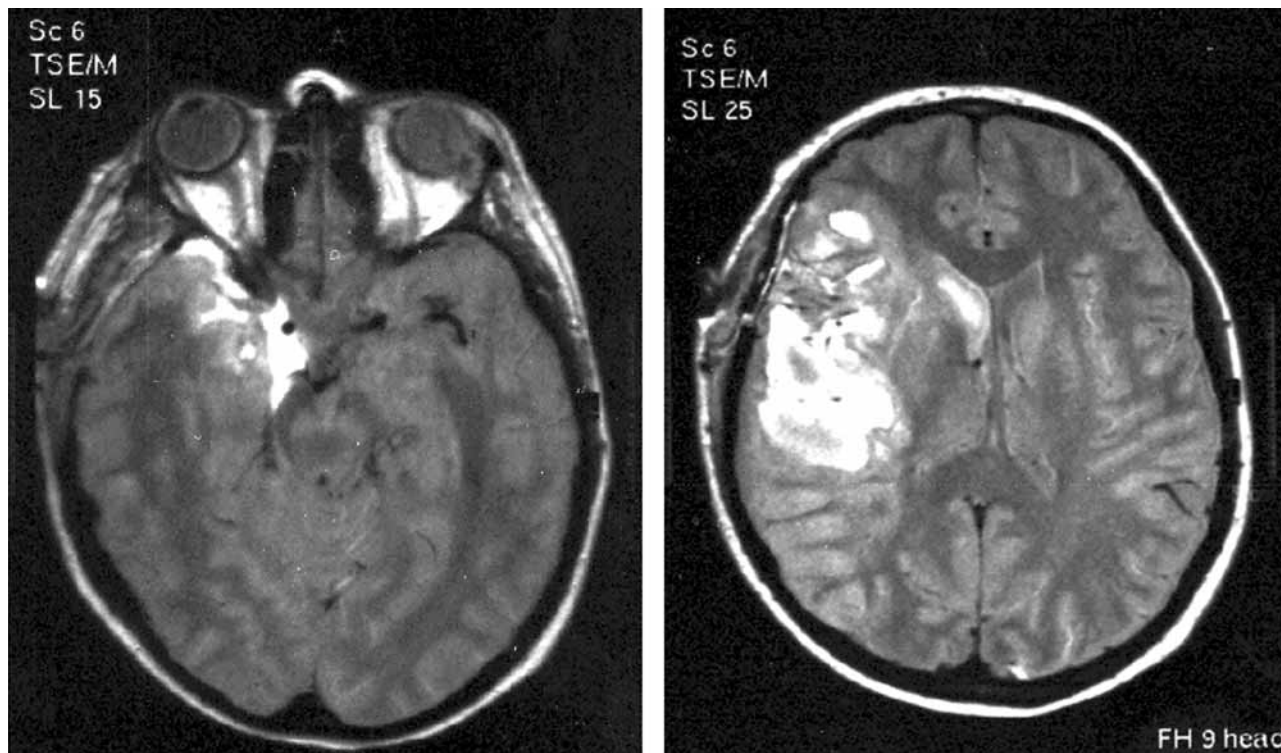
Cerebral MRI performed seven days after onset. A : Axial slice showing the haemorrhage as a T2-hyperintense signal expanding to the perimesencephalic cisterna. B : Axial slice showing the infarct as an extensive T2-hyperintense signal in the right frontoparietal lobes and the haemorrhage at the head of the right caudate nucleus.
